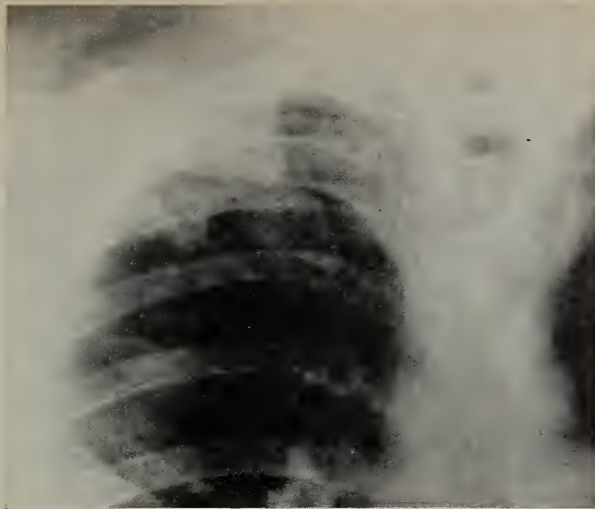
Detailed x-ray view of right upper lobe of adult male patient with reinfection tuberculosis. The infiltration is in a characteristic location in the apical segment.
